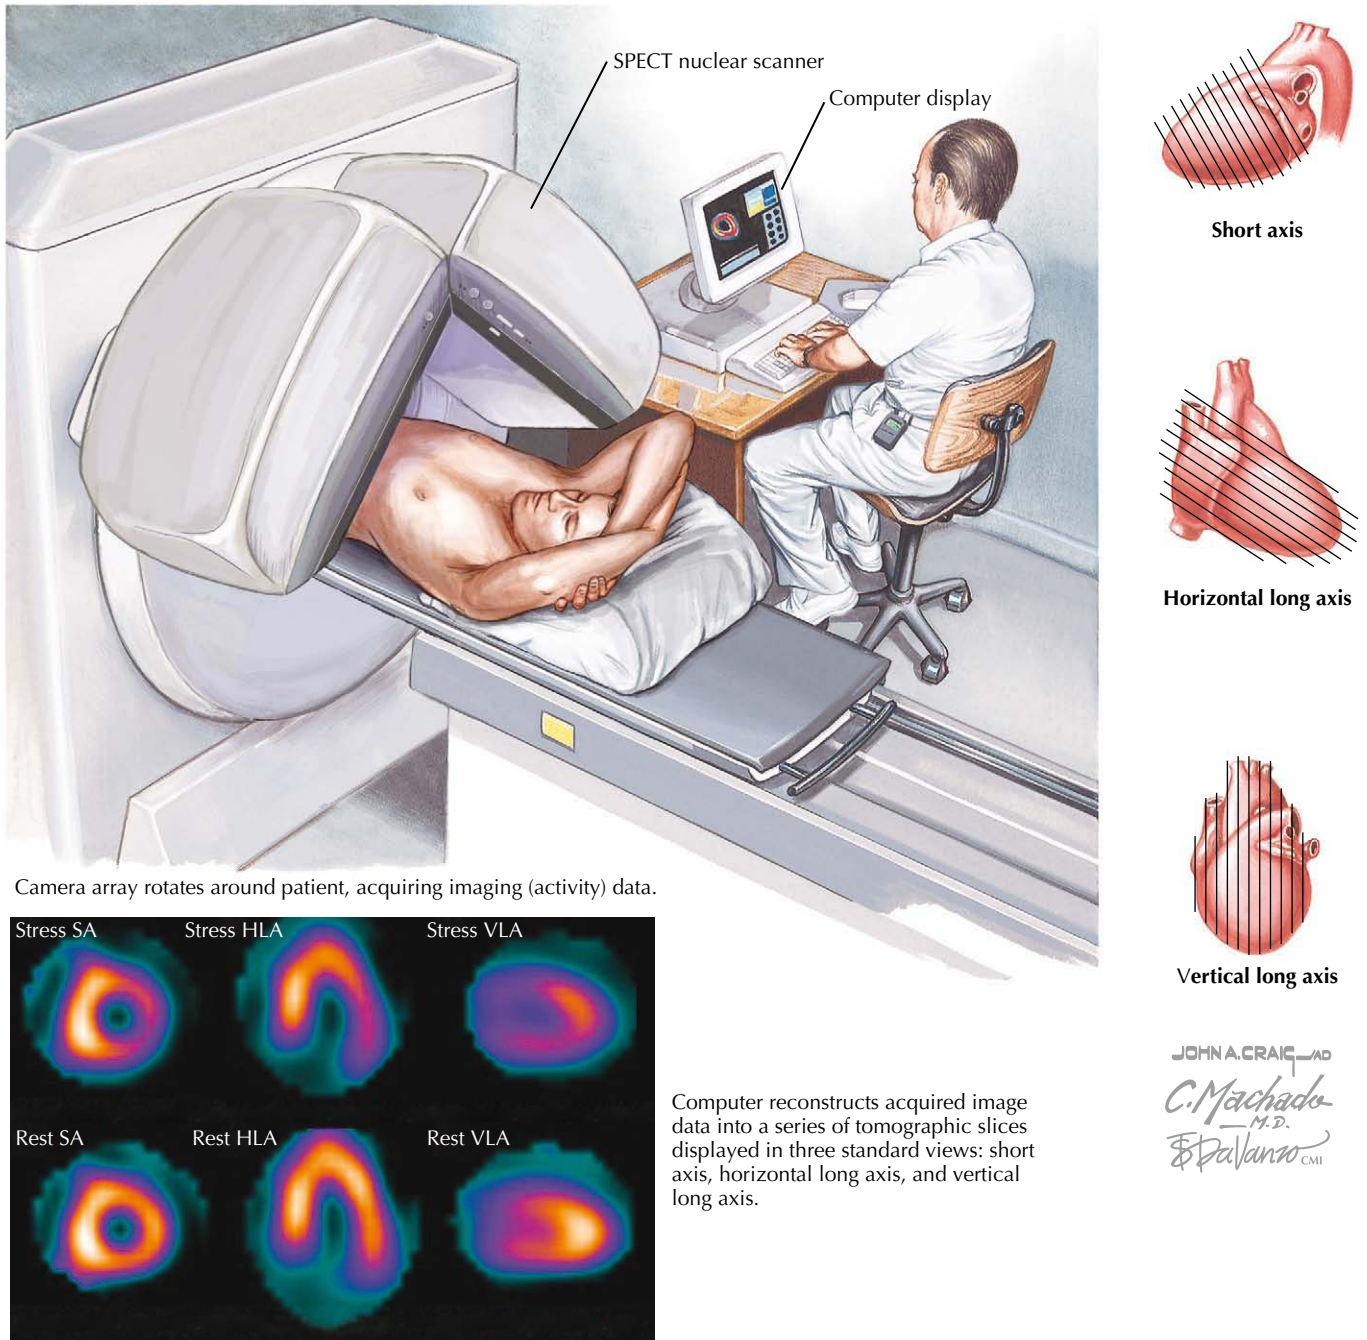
Stress nuclear imaging by single-photon emission CT (SPECT). HLA, horizontal long axis; SA, short axis; VLA, vertical long axis.
